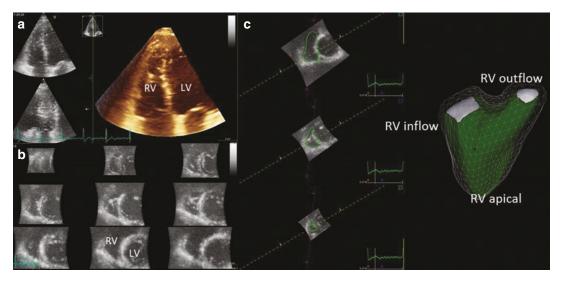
Assessment of right ventricular volumes and function with 3-dimensional transthoracic echocardiography. From a focused apical view of the right ventricle (panel a), visualizing simultaneously two orthogonal planes (the 4-chamber view in the left upper corner and the apical right ventricular outflow tract view in the left bottom corner) and the 3-dimensional full-volume
